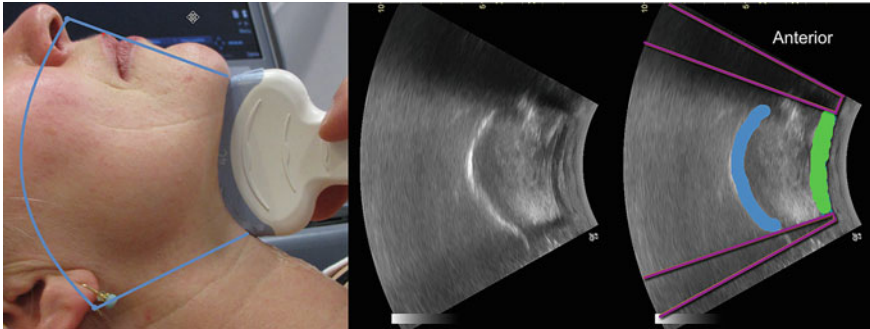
Mouth and tongue. Left: The curved, low frequency transducer and the area covered by the scanning (light blue). Middle: The resulting ultrasound image. Right: The dorsal surface of the tongue (blue), muscles in the floor of the mouth (light green). The shadows (purple) from the mentum of the mandible anteriorly and from the hyoid bone posteriorly (Courtesy The Scandinavian Airway Management Course, Airwaymanagement.dk)
